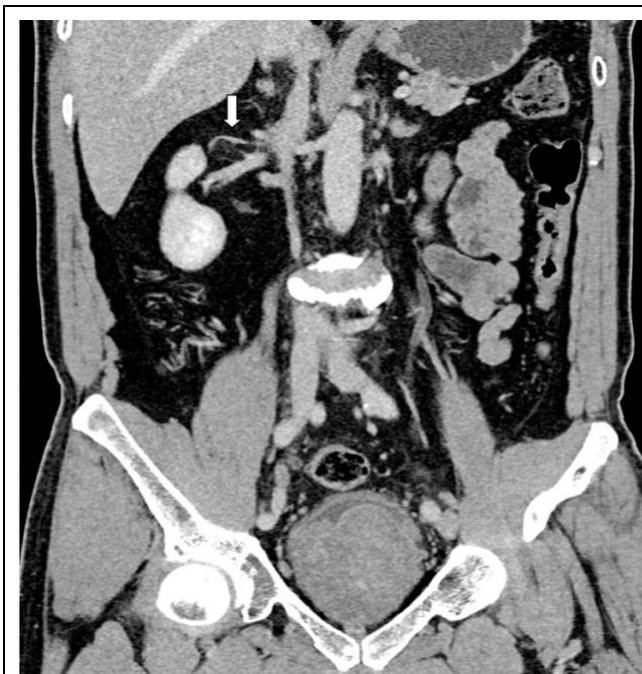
Contrast-enhanced coronal CT image shows fatty tumour thrombus (arrow) invasion into right renal vein.
